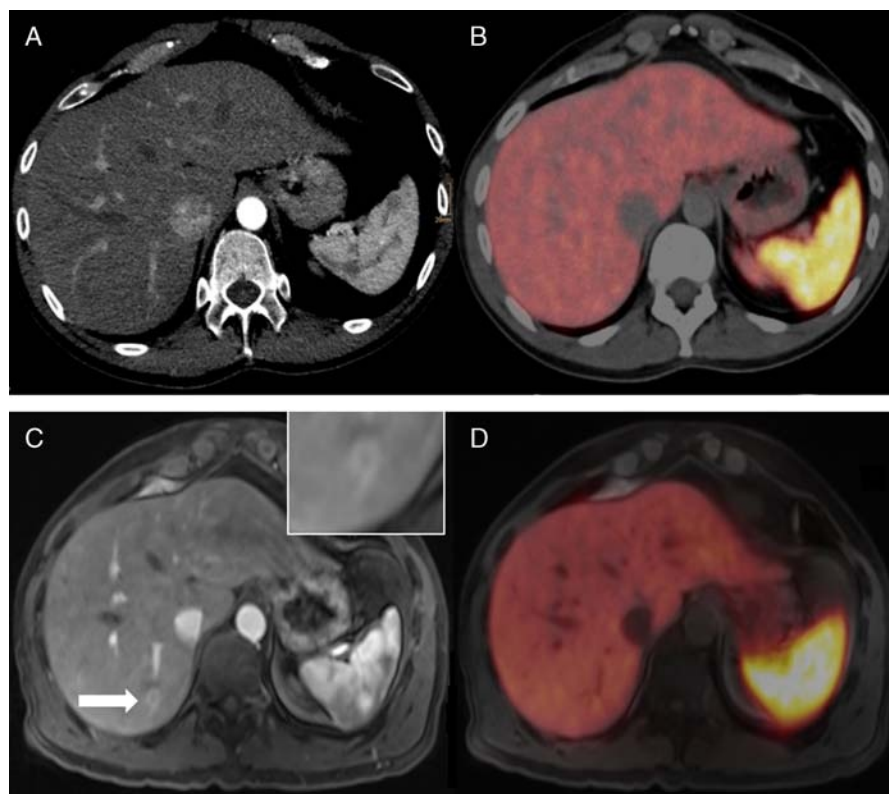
A 37-year-old man after surgically resected primary NET (G1) of the small bowel. In the arterial contrast medium phase in PET/CT (A), no focal liver lesion could be detected. In the corresponding fused PET images (B), no suspicious focal uptake was found in the liver parenchyma. PET/MRI revealed a small lesion in liver segment VI (C, T1 VIBE, arterial contrast medium phase) and focal uptake on the corresponding fused PET images (D).
